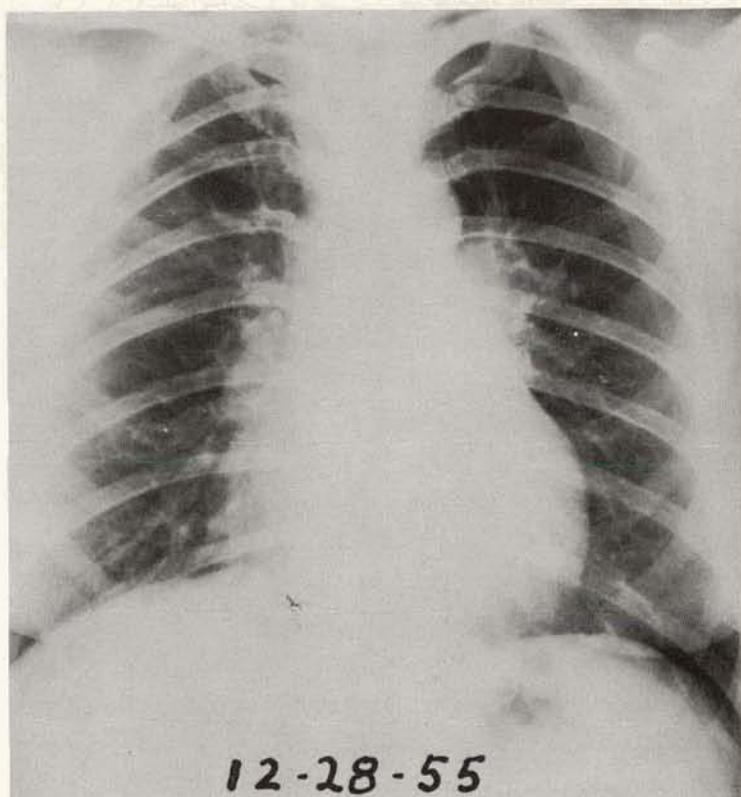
Same patient as shown in Figures 76 and 77. Roentgenograph of chest, December 28, 1955. Patient had been taking desiccated thyroid, 4 grains daily, since September 1, 1955.
